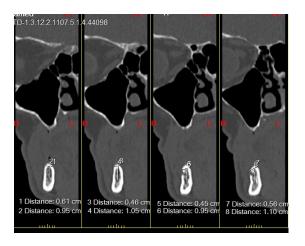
CT dentascan showing the distance from the alveolar crest to mental foramina.
